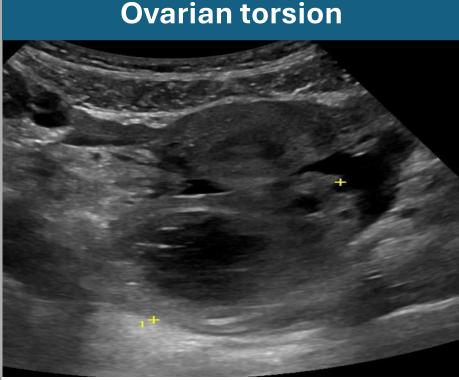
A transabdominal ultrasound performed for right iliac fossa pain and vomiting shows an enlarged right ovary, medially displaced in the pelvis, with surrounding free fluid. A 3 cm haemorrhagic follicle within the ovary appears to have acted as the lead point for ovarian torsion. This was initially misinterpreted as an ovarian mass, and MRI and gynae MDM discussion was recommended.
